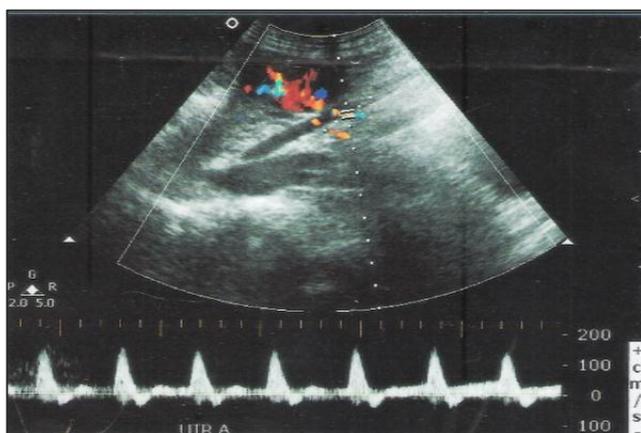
Uterine Artery Doppler Showing Early Diastolic Notch with S/D Ratio and Elevated PI and RI
